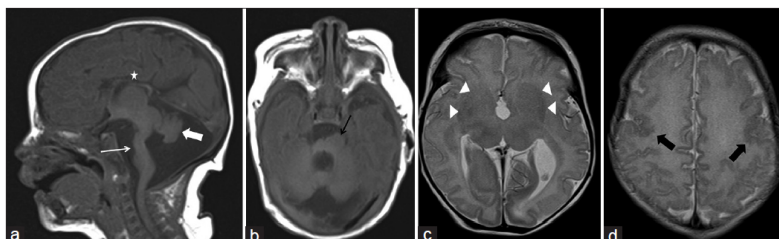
Sagittal T1 (a), axial T1 (b), and axial T2 (c, d) sections of MRI brain showing "Z"-shaped or kinked brainstem (white arrow) which is hypoplastic, has partial midline cleft with asymmetrical focal bulges involving left hemipons (black arrow), small and dysplastic cerebellum (white block arrow), fused basal ganglia structures with dysgenesis of anterior limbs of internal capsules ("absent/dysgenetic ALIC sign," white arrowheads), diffuse bilateral perisylvian polymicrogyria (black block arrows) and hypoplastic corpus callosum (asterisk). Imaging findings are suggestive of tubulinopathy
